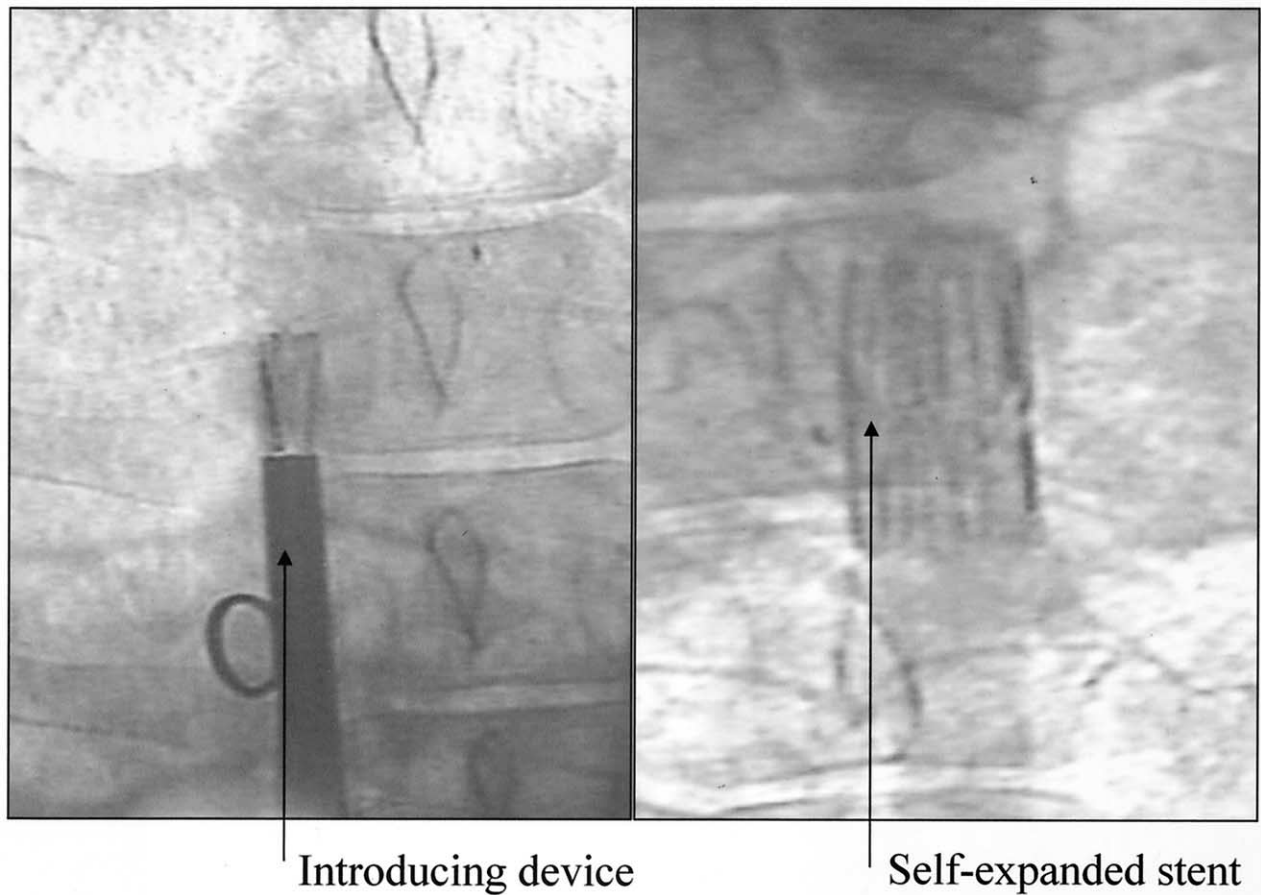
X-ray control of placement of endovascular stent grafts.
